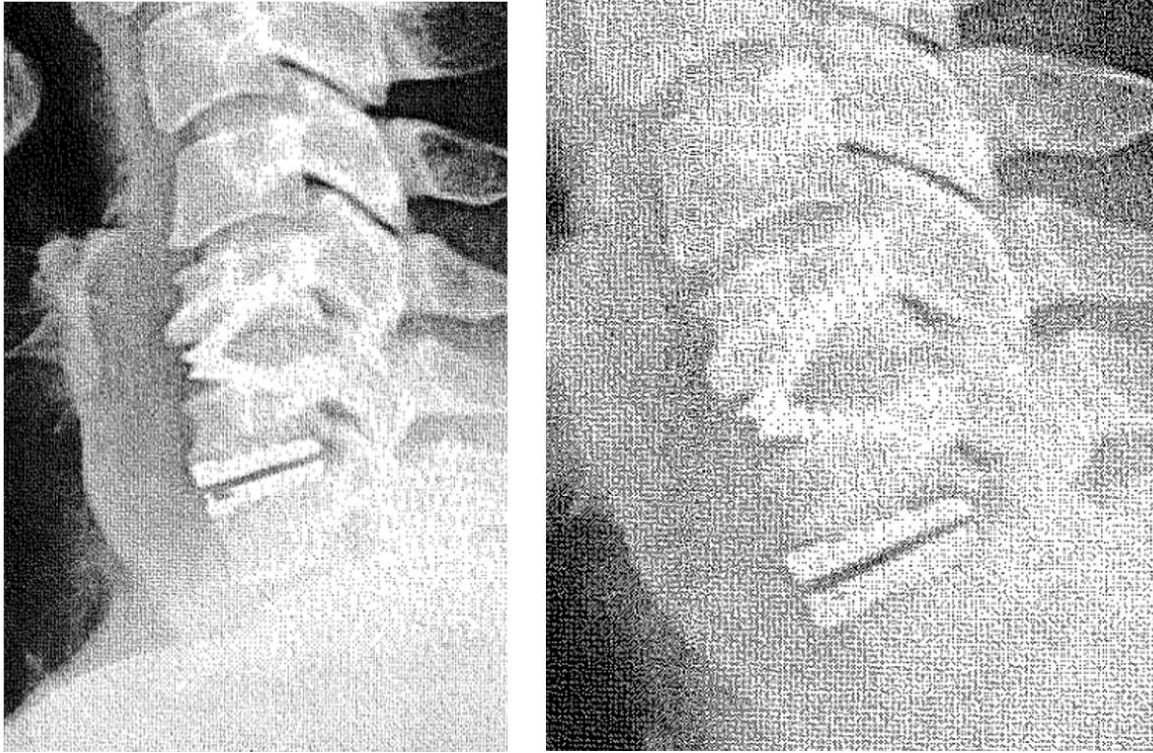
(Left) Pre-operative and (Right) Post-Operative radiographs from a device with reported migration of the inferior and superior component.
